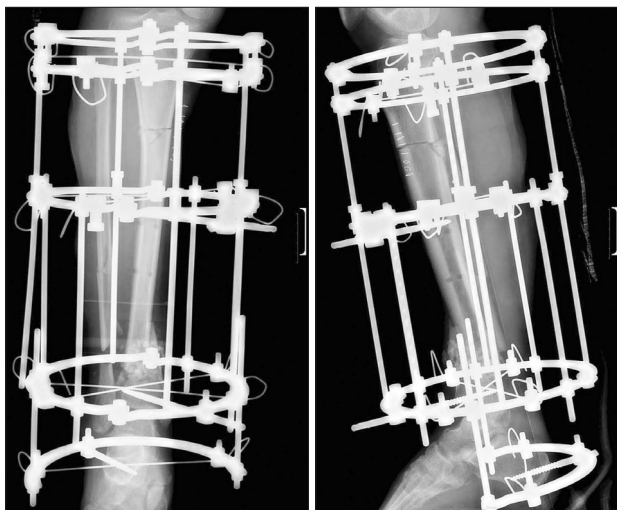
Radiographs showing corticotomy at proximal metaphysis of the tibia by Ilizarov technique.
